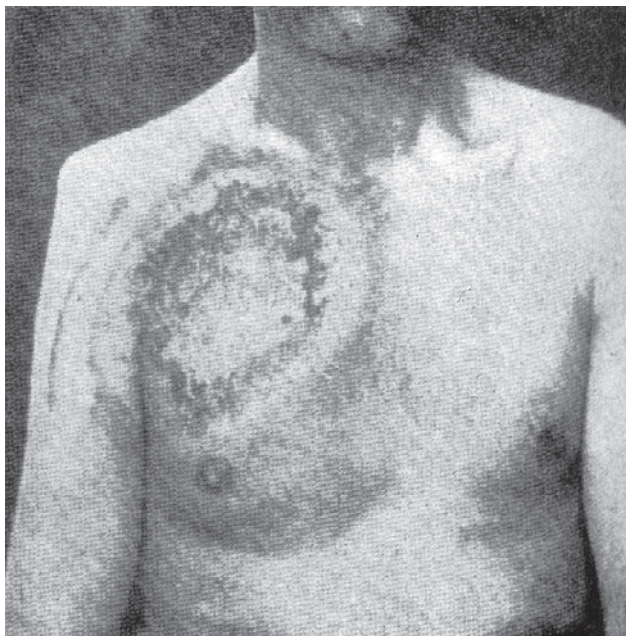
Radiation injury to the skin of a Spanish-American War soldier as a result of an x-ray examination, 1898. The radiation exposure necessary to cause this type of burn is greater than 600 R. Current technology allows a radiologist to obtain better diagnostic information at exposures that are 1,000-fold lower than the exposure this patient received. Reproduced from: Borden WC. *The Use of the Roentgen Ray by the Medical Department of the United States Army in War with Spain (1898)*. Washington, DC: Office of The Surgeon General, DA; 1900.
